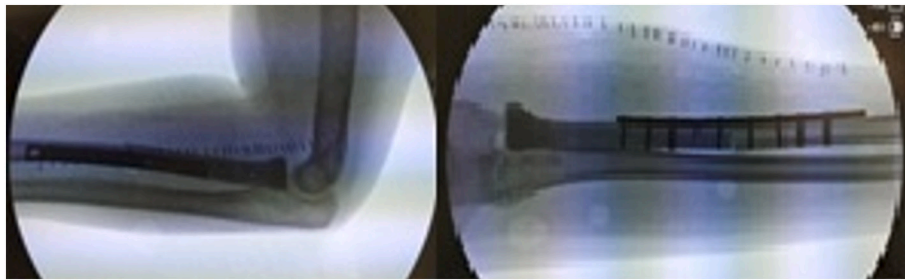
Shows immediate anterior-posterior and lateral radiographs of the left elbow after application and fixation of the implant.
